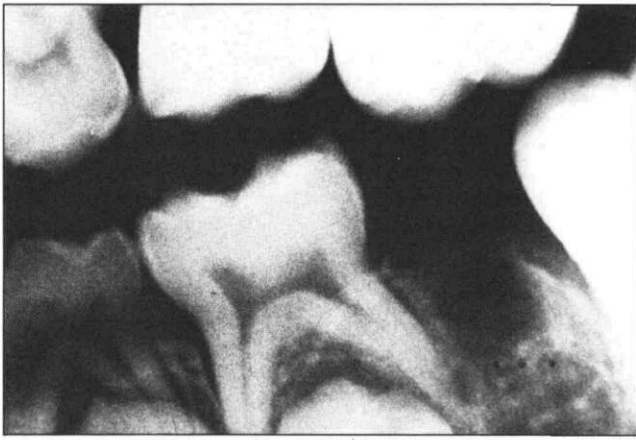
Bitewing radiograph showing multilocular radiolucent lesion, distally displaced mandibular first permanent molar, and supraeruption of the maxillary left first permanent molar.
